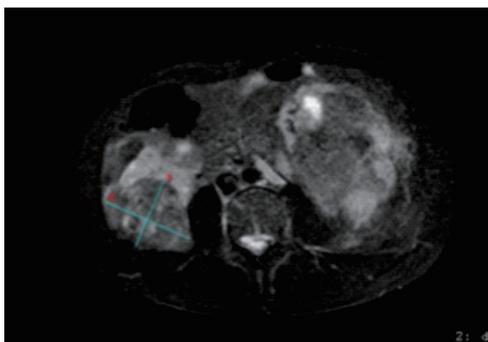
Fatty content in upper pole of the right kidney was showed on abdominal MRI
